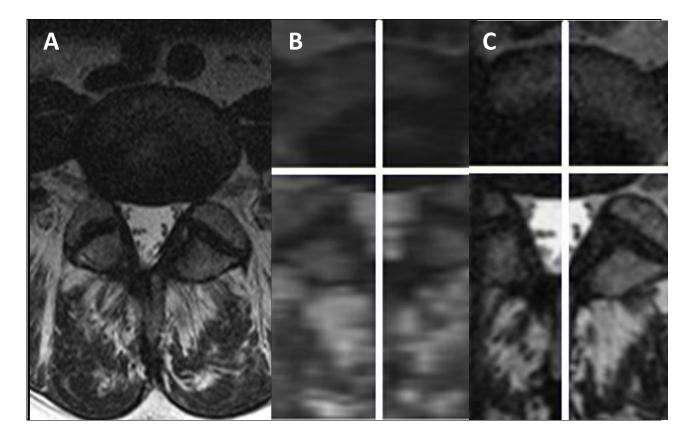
Axial L45 T2-weighted 2D-FSE images of the same subject. A) Traditional axial plane 2D-FSE (gold-standard). B) Reconstructed axial image from traditional 2D-FSE sagittal plane acquisition (poor option). C) Reconstructed axial image from 3D-TSE sagittal acquisition (potential alternative).
